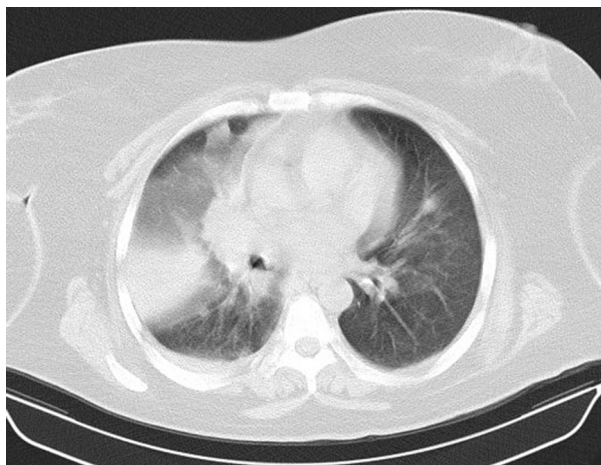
CT scan of parenchymal consolidation in the upper right pulmonary lobe.
